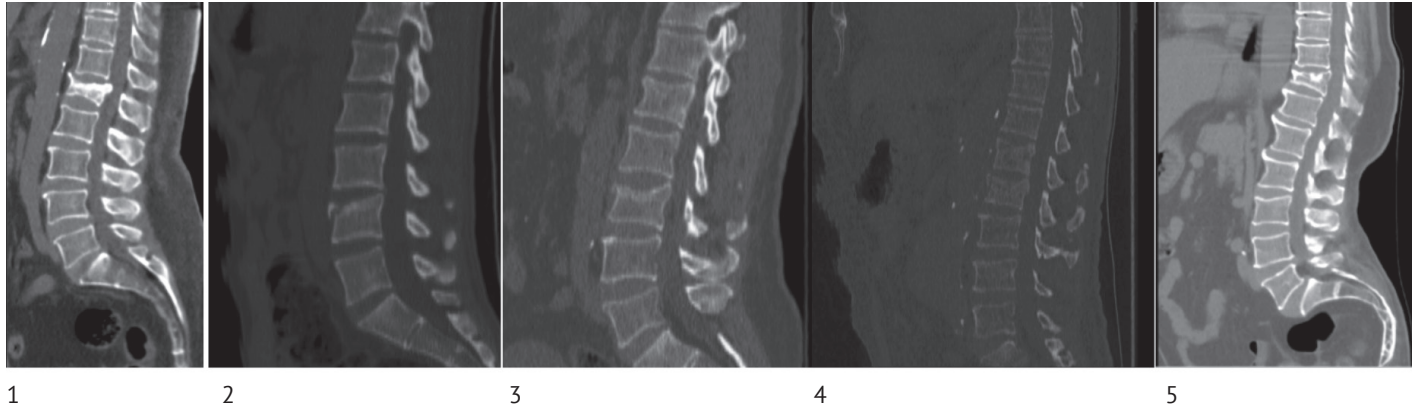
The sagittal reconstructed view of thoracolumbar CT findings as discussed in Table 1
